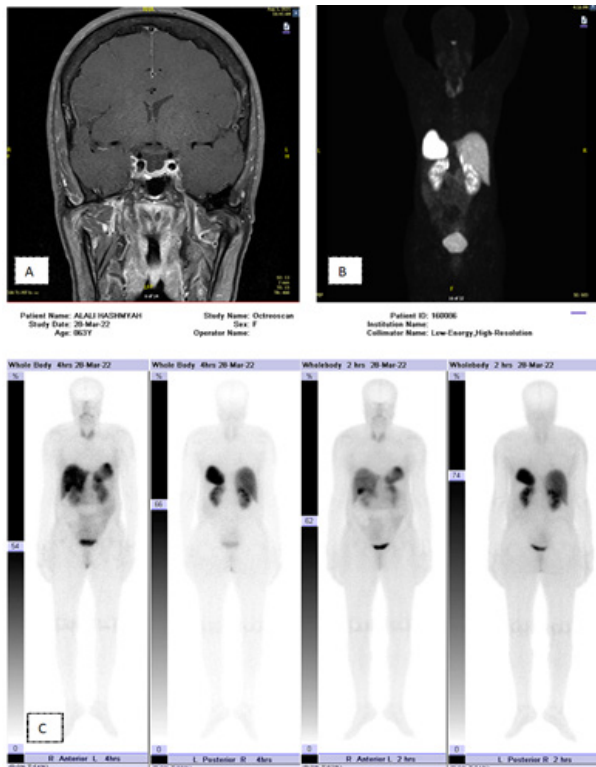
A: MRI shows empty Sella, B: DOTATATE PET/CT showing receptor activity in the pituitary gland due to physiological somatostatin receptor expression & C: Octreotide scan shows physiological radiotracer distribution with no abnormal activity to suggest neuroendocrine tumor
